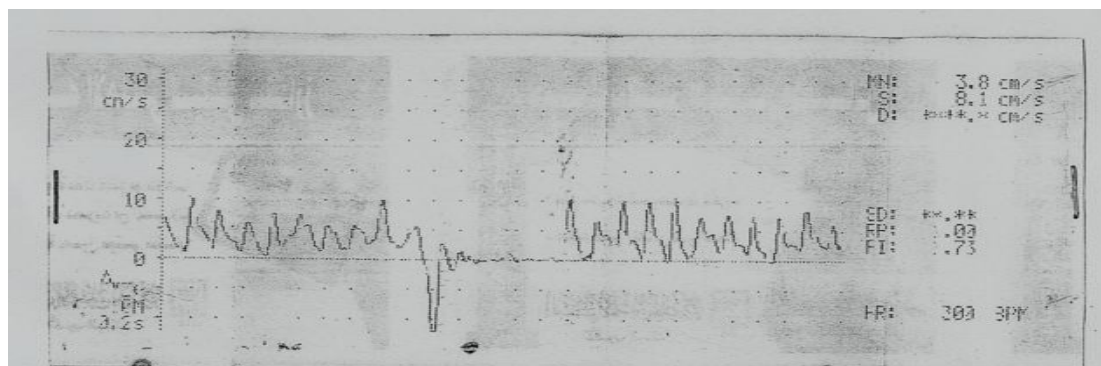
Doppler ultrasound record of testicular blood flow in normal control group.
